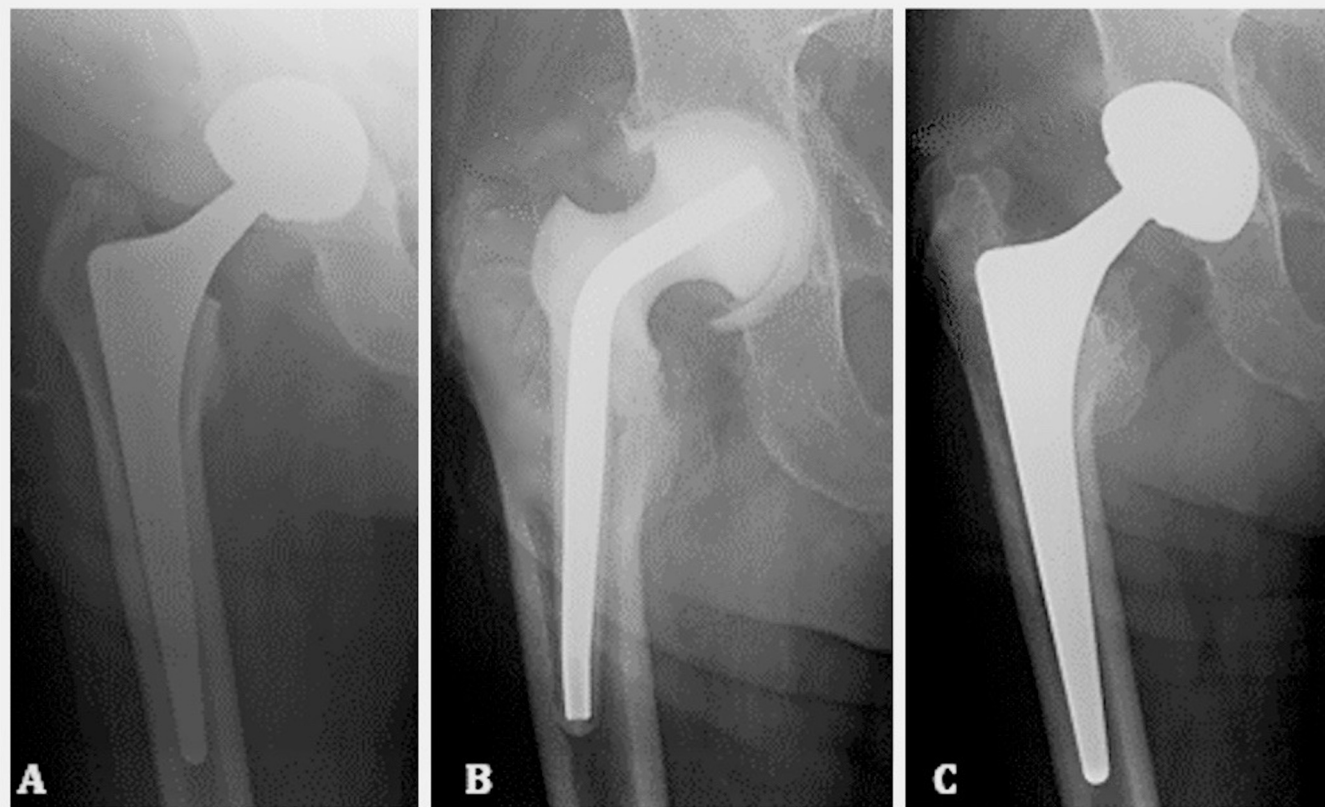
Radiographic example of two-stage revision for hip PJI with primary components. Pre-operative X-ray of infected THA (A), radiographic assessment of spacer placement 6 weeks after the explantation stage (B) and final assessment of completed two-stage procedure at 3 years (C).
